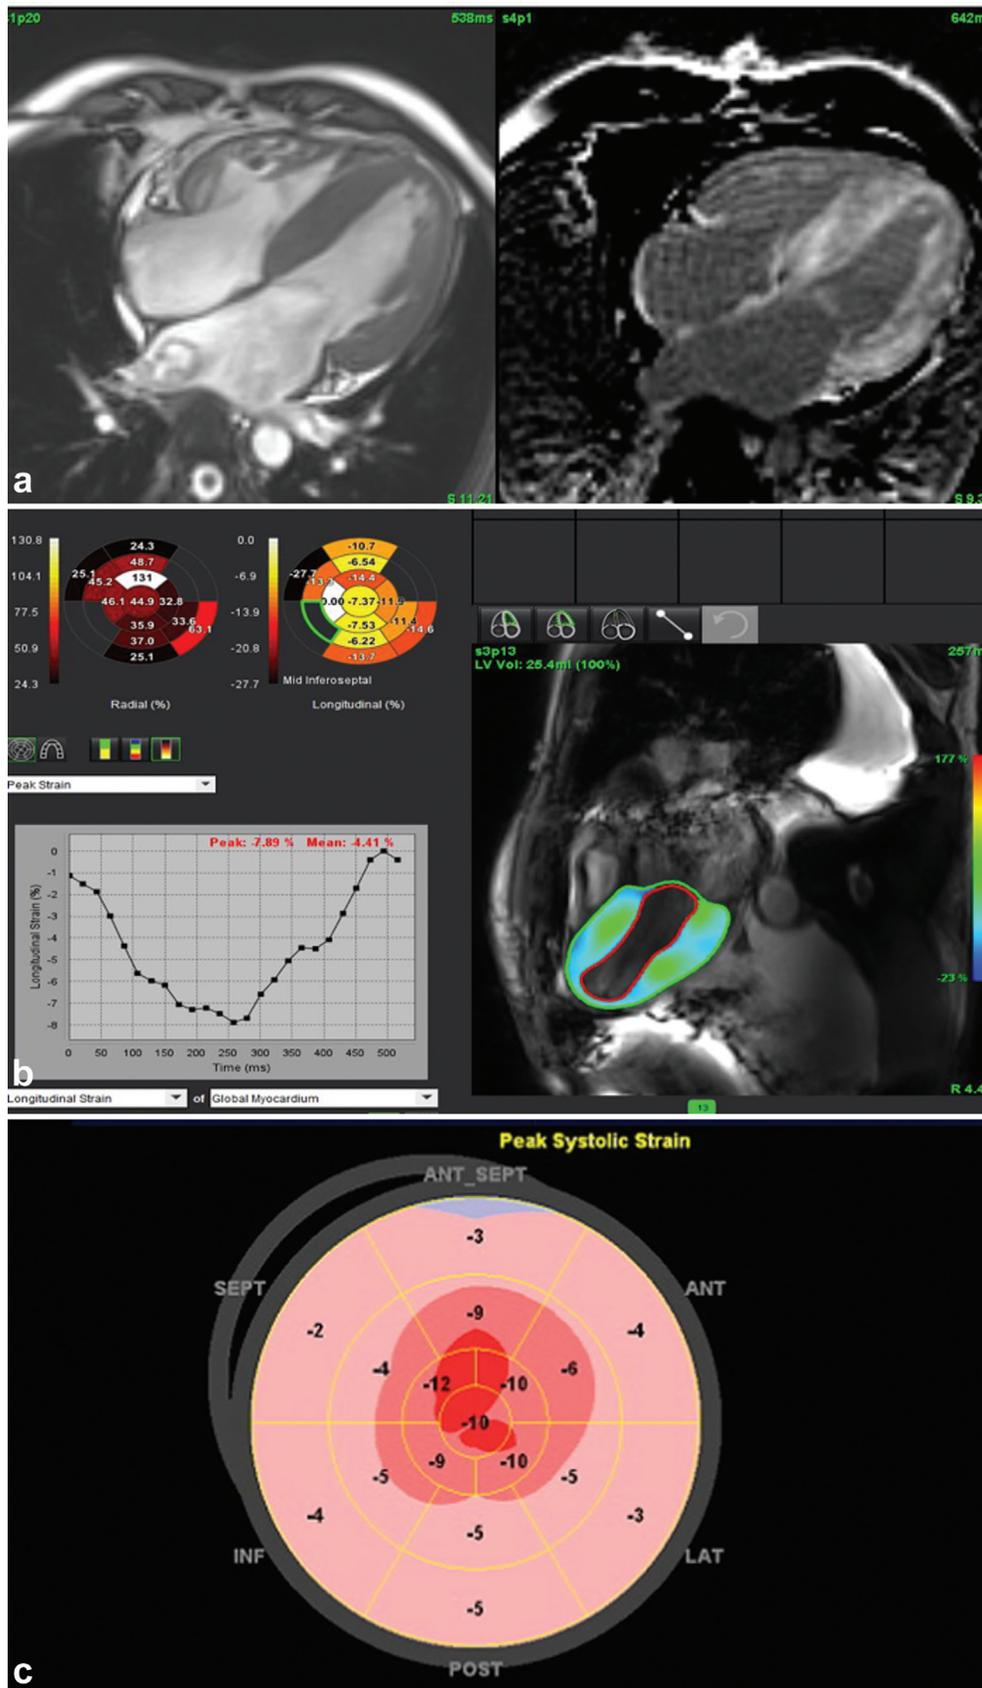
Cardiac amyloidosis with hypertrophy of left ventricular myocardium and diffuse subendocardial hyperenhancement (top image). There is reduction of global longitudinal strain is values with relative apical sparing. This finding is described as 'cherry on top' appearance in speckle tracking echocardiography (bottom image).
